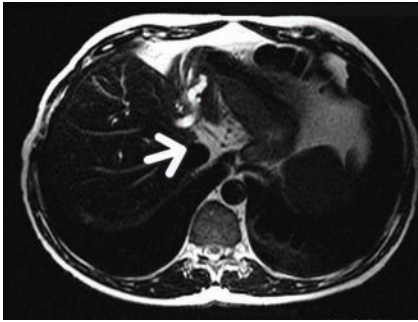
Magnetic resonance imaging showed predominant dilatation of the left biliary tree, atrophy of left hepatic lobe particularly lateral segment, and wall thickening near hepatic duct confluence (arrow).
